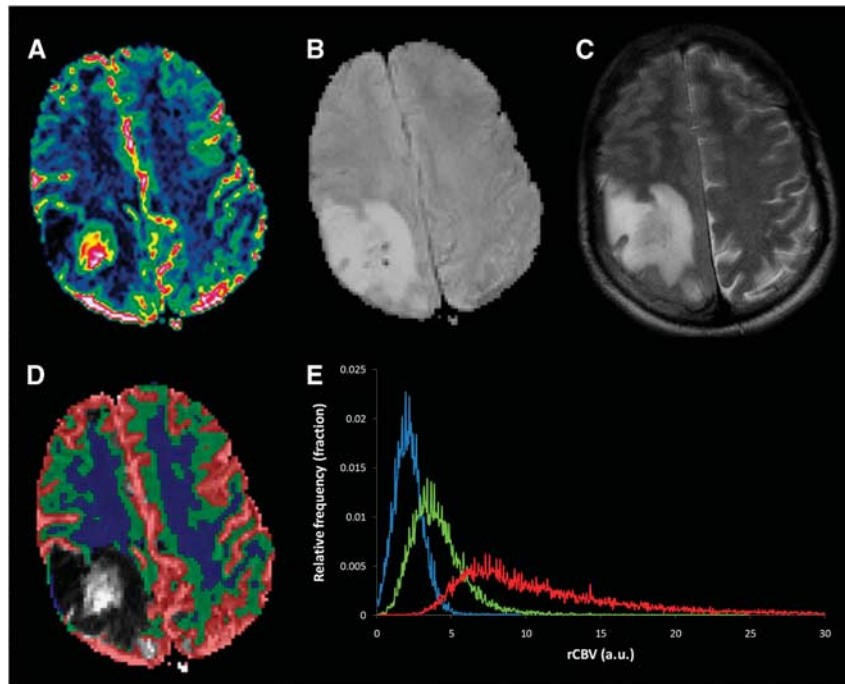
A sample case showing segmentation of tumor and classification of non-affected white/gray matter in a patient with glioblastoma (40-year-old male). Identification of gray- and white-matter tissue classes and blood was based on cluster analysis of the relative CBV (rCBV) values, resulting in the three tissue segments shown in panel D as overlays on the rCBV map shown separately in panel A. The three cluster classes are shown in red (high CBV), green (medium CBV), and blue (low CBV). The tissue cluster with the highest intensity in the baseline DSC scans (B) were excluded from the identified tissue classes and, as shown, the excluded region corresponds well with the area affected by the tumor according to the hyper-intense region in the T2-weighted image (C). The medium-CBV class corresponded well with the expected gray-matter regions and the low-CBV class with white-matter regions. Panel E shows the corresponding histogram distributions of the rCBV values (using the same color code as in panel D) for all slices for the respective tissue classes.
